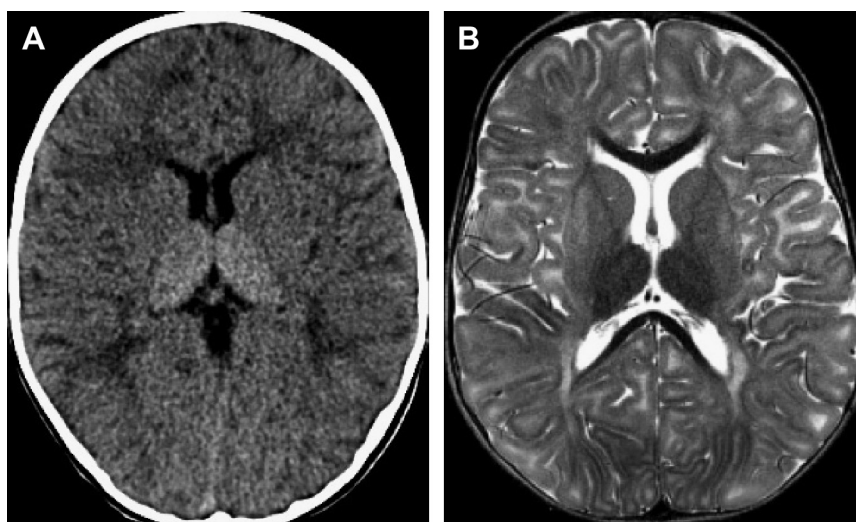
GM2 gangliosidosis (Sandhoff disease) in a 14-month-old girl with seizures, cherry red macula, and hypotonia. Noncontrast computed tomography of the head (A) demonstrates hyperdensity of the thalami and a suggestion of white matter hypodensity. Axial T2 MR imaging of the brain (B) demonstrates T2 hypointensity of the thalami corresponding to the computed tomography finding as well as basal ganglia and subcortical white matter signal increase. Note that the internal capsules and corpus callosum remain normal in signal intensity.
